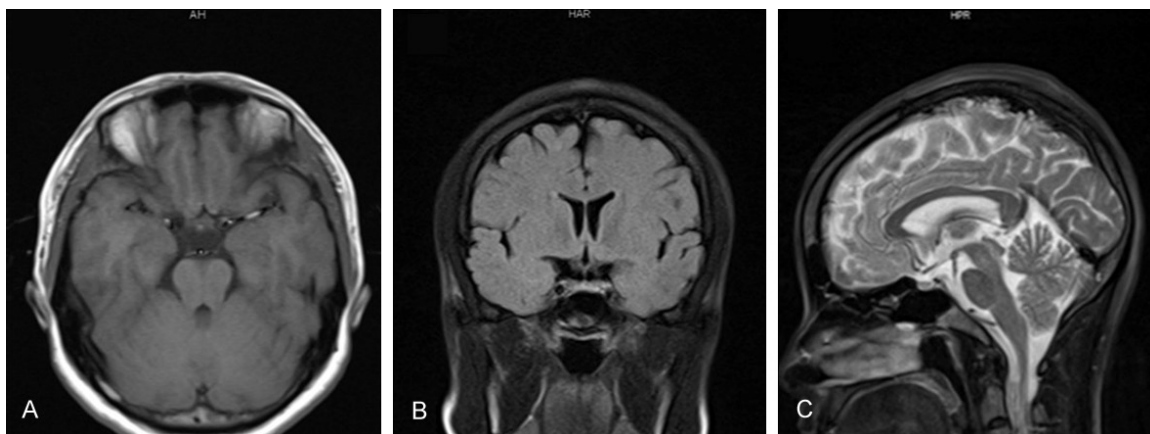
6 months after the operation. MRI shows total removal of the tumor (A-C).
